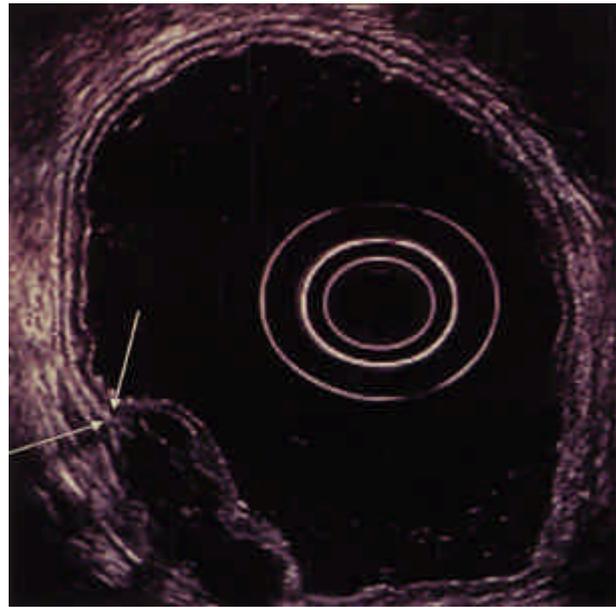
Endoscopic ultrasonography shows a cystic anechoic mass with multiple inner septations located in the third hypoechoic layer. The arrows indicate two muscular hypoechoic layers which consist of the muscularis mucosa and muscularis propria.
